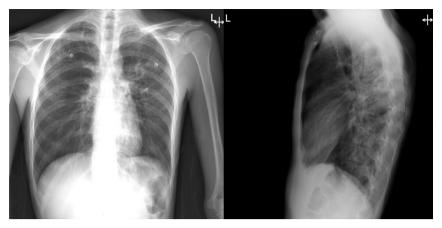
Posteroanterior and lateral chest roentgenography showing left suprahilar lucency.
